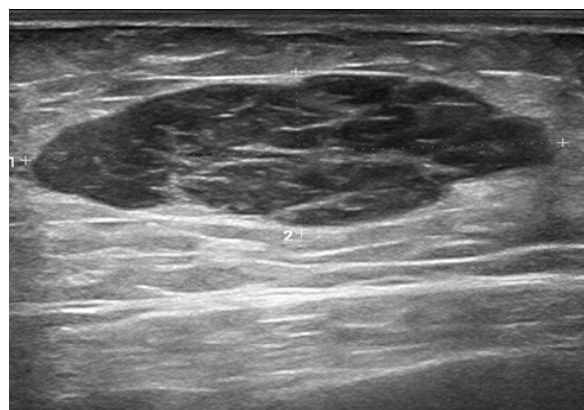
Dermatofibrosarcoma protuberans on the ultrasound examination shows hypoechoic well defined oval lesion in subcutaneous fat.
